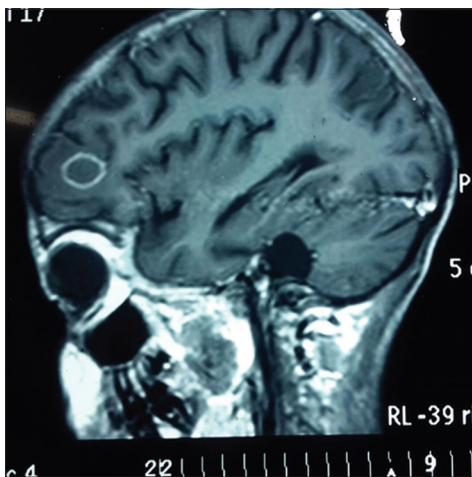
Magnetic Resonance Imaging (MRI) brain of a 13-year-old girl with generalized weakness and seizures on the 7th day of admission showing multiple granulomas in the brain probably of Tubercloid or lymphoid origin
